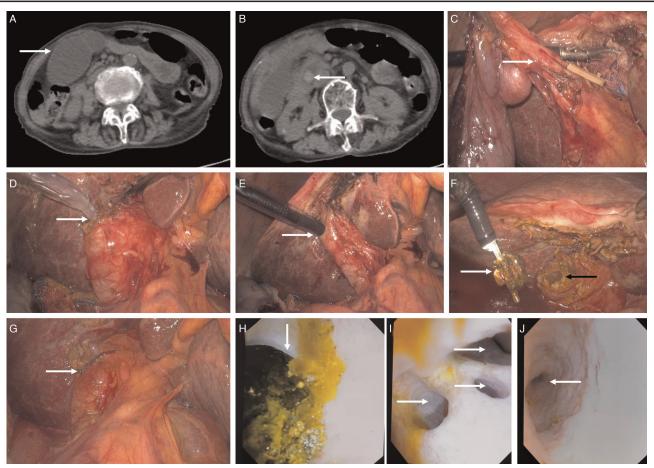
LTCBDE in a 93-year-old female patient with ACC combined with CBD stones. (A) CT showed enlargement and cholestasis of the gallbladder (arrow). (B) CT showed a stone (arrow) in the CBD. (C) Cystic duct of gallbladder (arrow). (D) A catheter (arrow) was inserted through the cystic duct for flushing; (E) Choledochoscope (arrow) was inserted through the cystic duct. (F) The stone (white arrow) was removed from the CBD through the choledochoscopic stone removal basket, the opening of cystic duct stump (black arrow). (G) Ligation (arrow) of cystic duct stump. (H) Stone (arrow) in the CBD. (I) The three opening of right hepatic duct branches (arrows). (J) Proximal opening (arrow) of the CBD. ACC: Acute calculous cholecystitis; CBD: Common bile duct; CT: Computed tomography; LTCBDE: Laparoscopic transcystic common bile duct exploration.
